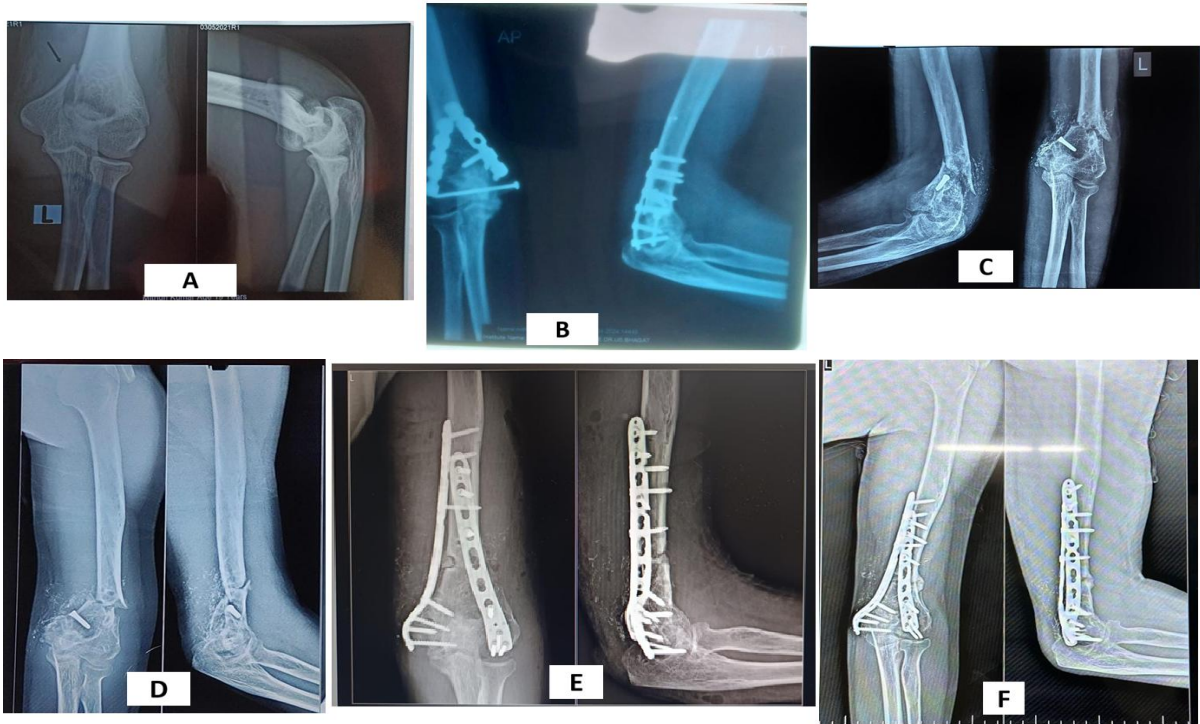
(A and B): Radiographs of a 23-year-old male showing a distal humerus fracture treated with dual plating; (C and D): Showing post implant removal distal humerus fracture due to trivial trauma; (E): Immediate post op x-ray treated with dual plating with bonegrafting; (F): 3 months post operative x-ray showing adequate consolidation.
